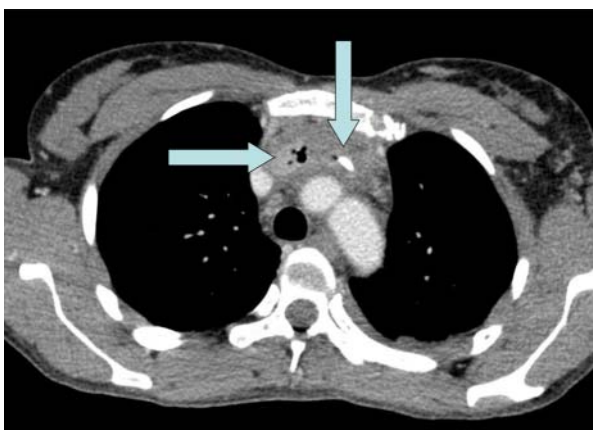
A thoracic CT scan revealing catheter-related (vertical arrow) partial superior vena cava thrombosis and complete innominate vein thrombosis, associated with gas bubbles (horizontal arrow).
